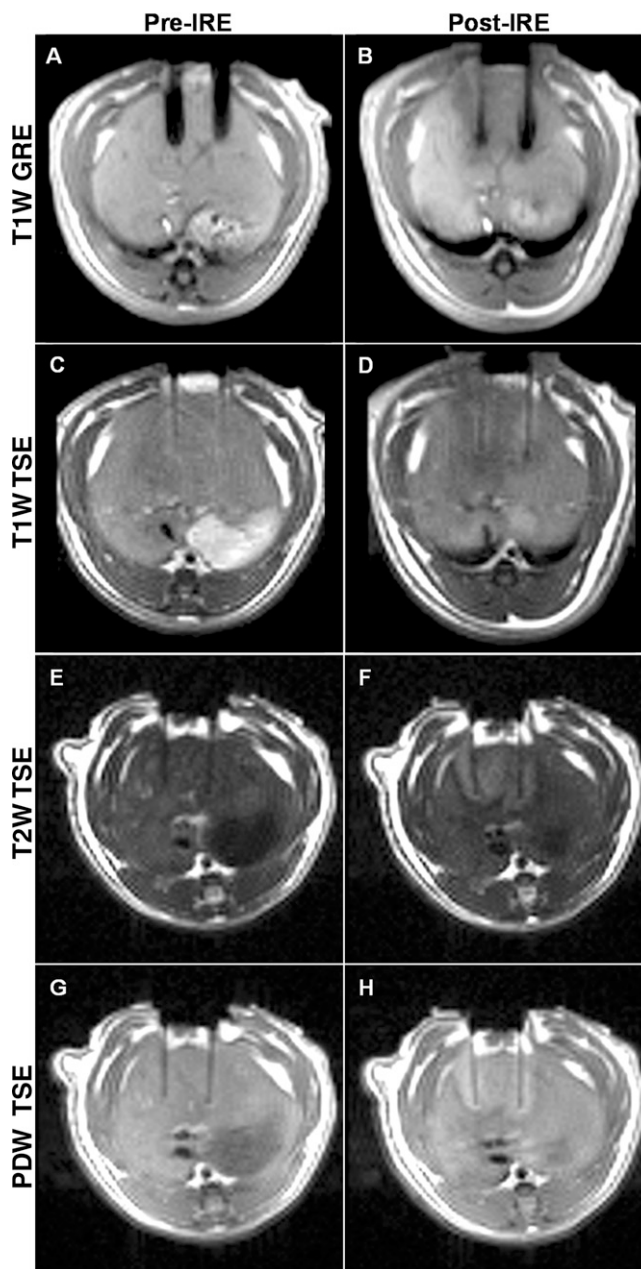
Representative MR images acquired parallel to the electrodes before (*Pre-IRE*) and immediately after (*Post-IRE*) IRE with 2500-V pulses. A, B, T1-weighted (T1W) GRE images; C, D, T1-weighted TSE images; E, F, T2-weighted (T2W) TSE images; G, H, proton-density-weighted (PDW) TSE images. Bipolar electrode positions are depicted as signal voids. Ablation zones are hypointense on T1-weighted images and hyperintense on both T2- and proton-density-weighted images.
